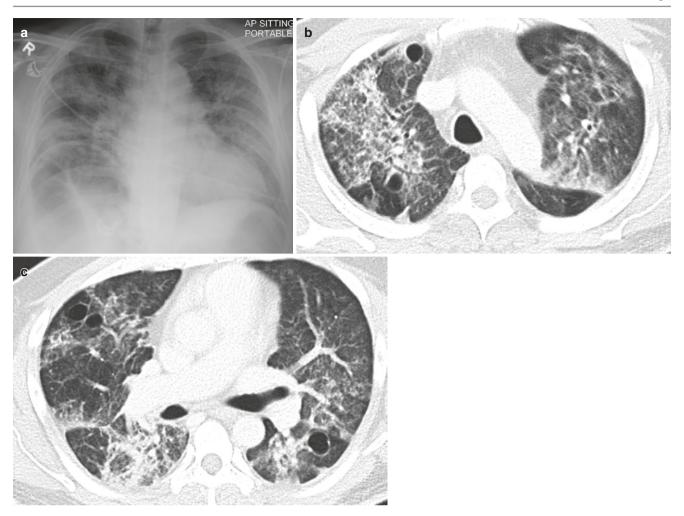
PCJ infection with striking subpleural sparing. (a) Frontal chest radiograph shows extensive bilateral reticular opacities and ground-glass opacities. (b, c) Axial HRCT images show marked septal
